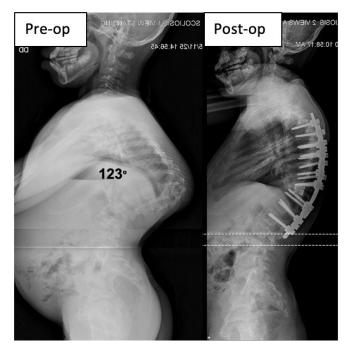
Radiographic images of case examples.
